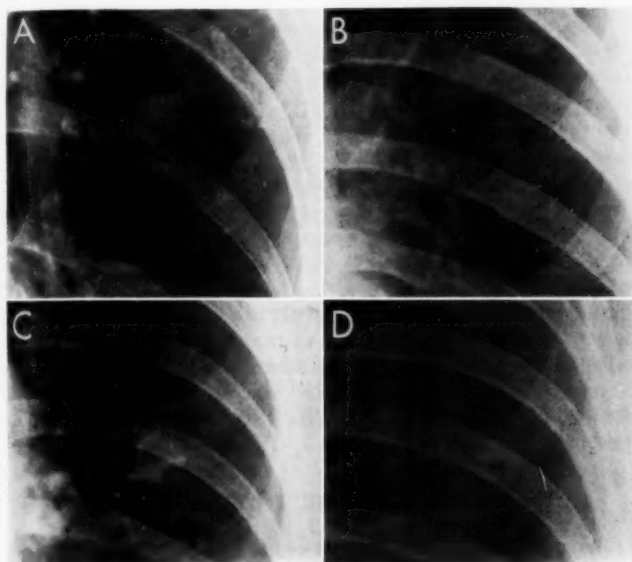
Spot roentgenograms of 4 solitary pulmonary nodules closely resembling each other in size, shape and location but differing completely as to cause. One is a bronchial carcinoma (*D*); but to differentiate clinically between this and the other three (*A*, *B* and *C*) cannot be done by any method other than thoracotomy.
